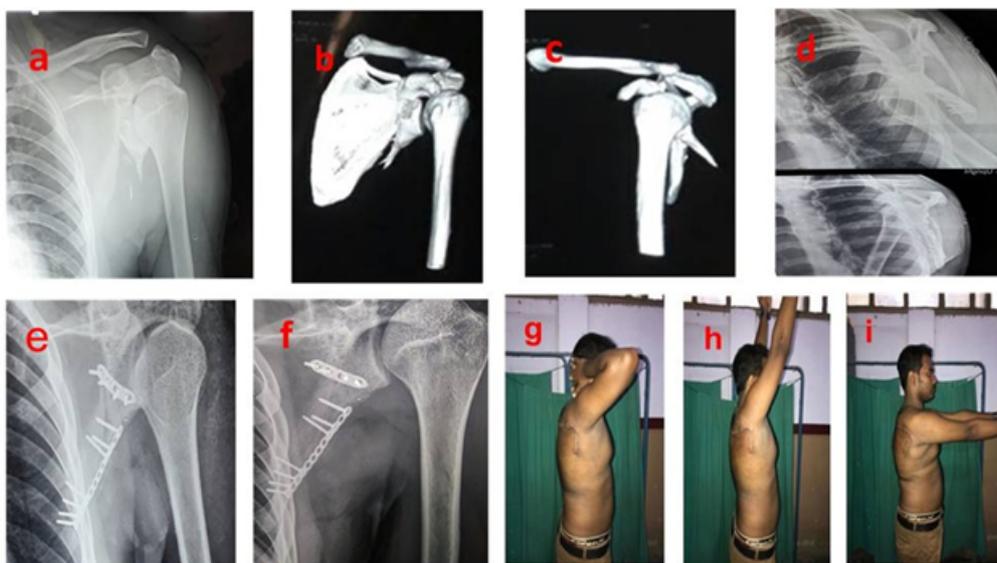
(a,b,c) X-ray and CT of a 25 year male patient with AO type F0/OTA 14C1 type Extra-articular glenoid neck fracture with inferior extension, (d,e) 4th post-op month xrays. (f) 4th post operative year x-ray, (g,h,i) 4^{yr} follow up clinical image
